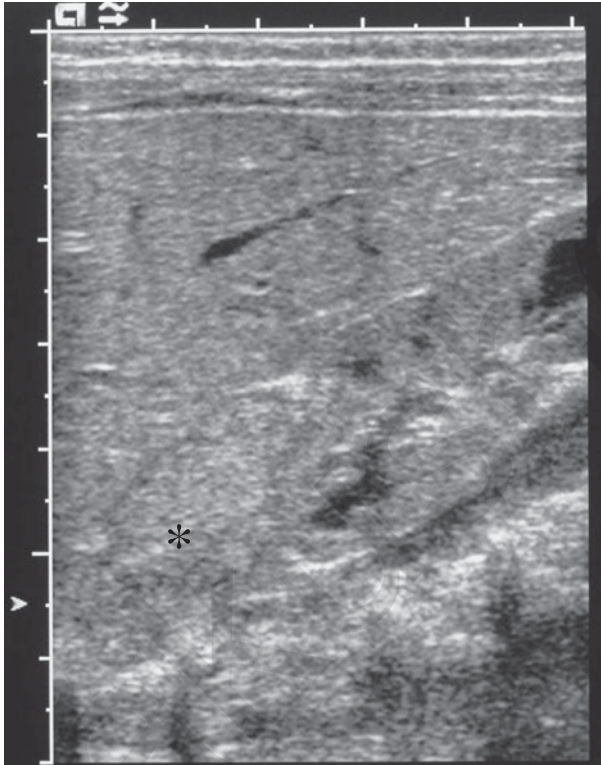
Ultrasound neuroblastoma. In contrast, this suprarenal abnormality is clearly solid, representing an adrenal mass in a child with neuroblastoma (asterisk). (L = liver, K = right kidney.)
